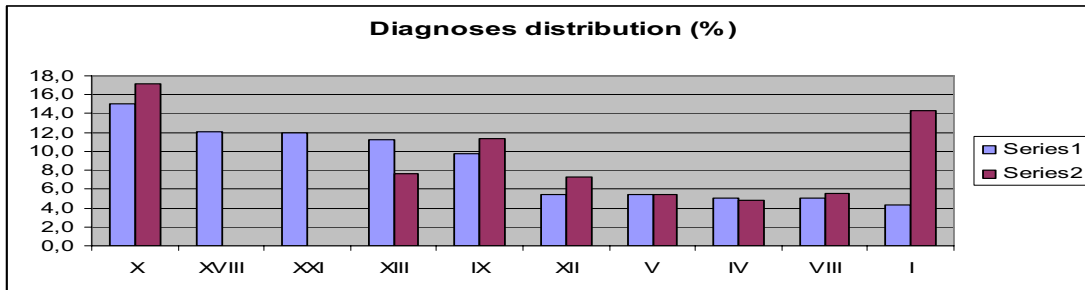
Distribution of diagnoses in top-ten ICD-10 chapters (left bars) and corresponding SNOMED CT concepts (right bars). (The table is truncated at a cut-off level of 5 %).
